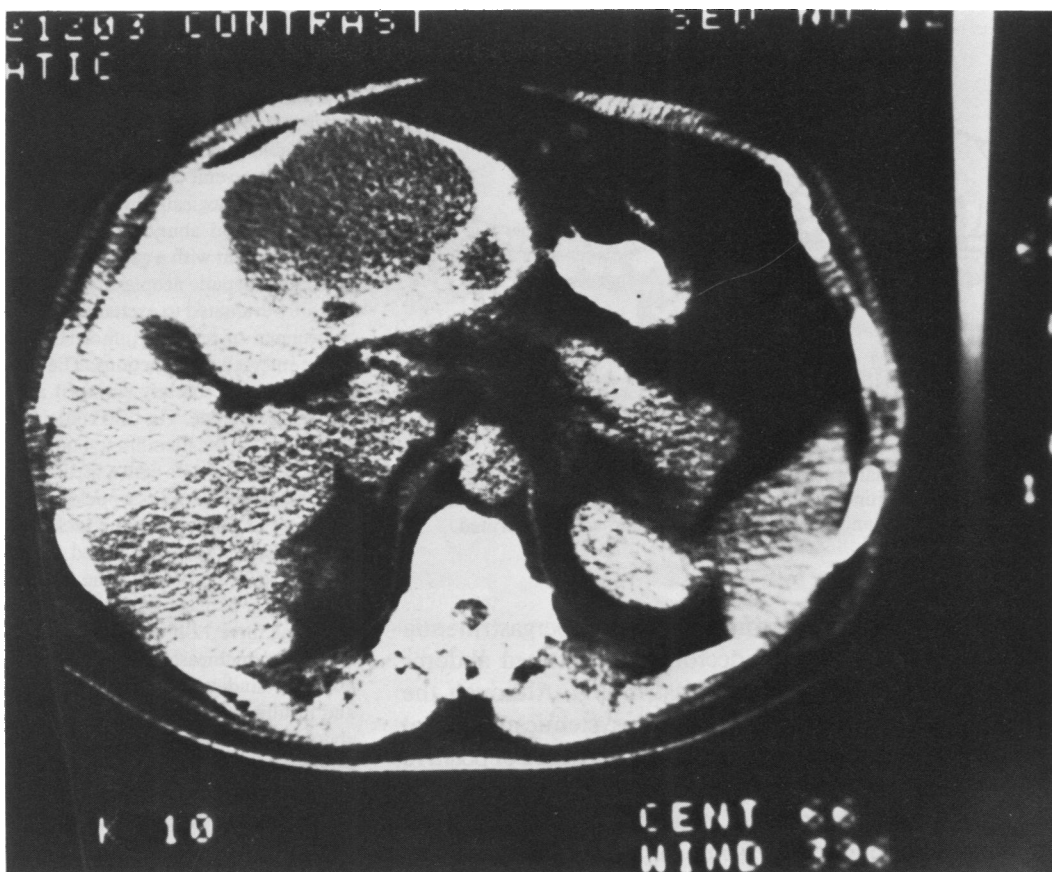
Case 4. CT of abdomen showing large, biloculated cyst replacing most of medial segment of the left lobe of the liver.
